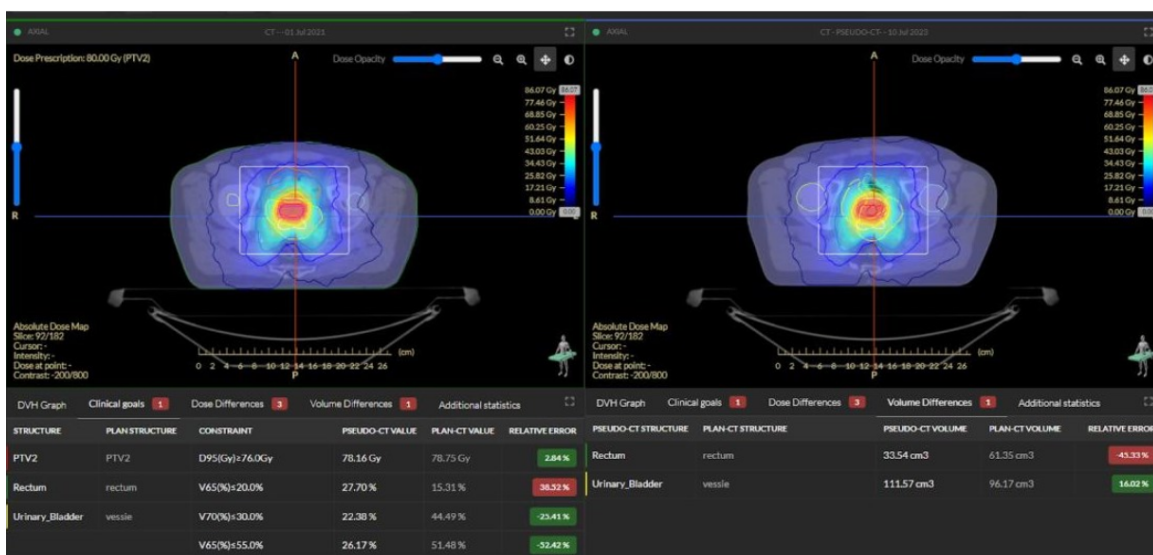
Example of one treatment fraction evaluated using AdaptBox. On the left, the dose calculated on the planning CT; on the right, the dose calculated on the synthetic CT.
